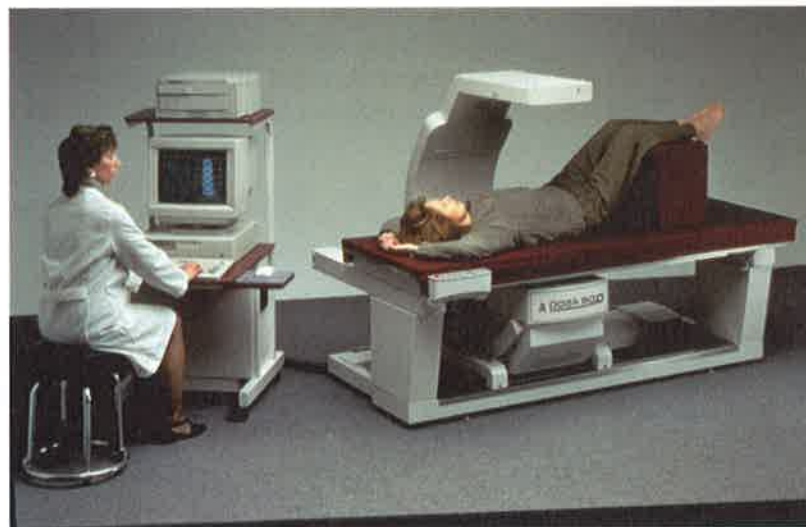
Patient undergoing bone density test or dual energy x-ray absorptiometry (DEXA or DXA). (From Greer I et al: *Mosby's Color Atlas and Text of Obstetrics and Gynecology*, London, Mosby, 2001.)
